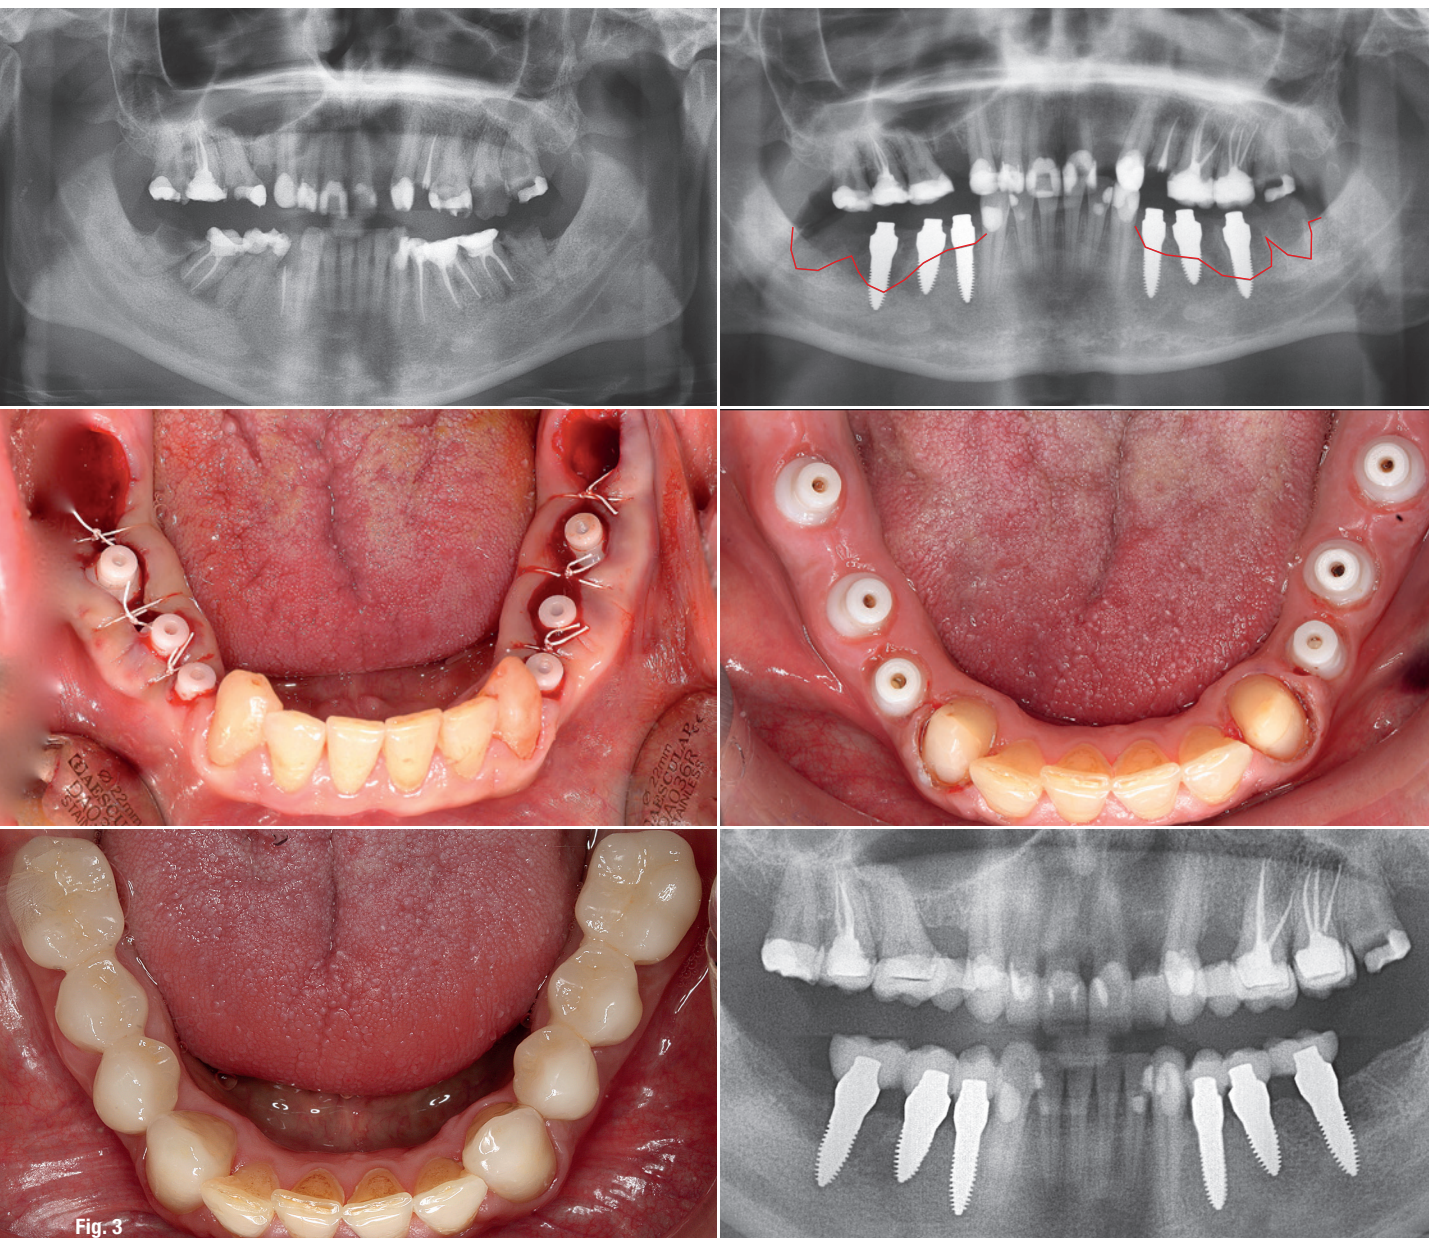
During a surgery with immediate implant placement, the implants were placed at the desired level of the regenerated bone. The unharmed periosteum as well as the attached gingiva were fixed over the tulip formed widening (“sunshade principle”) of the SDS ceramic implant, which results in a stable cavity. The panoramic X-ray shows the final restoration with e.max crowns after only 2.5 months postoperatively with complete bone regeneration at the desired level.
